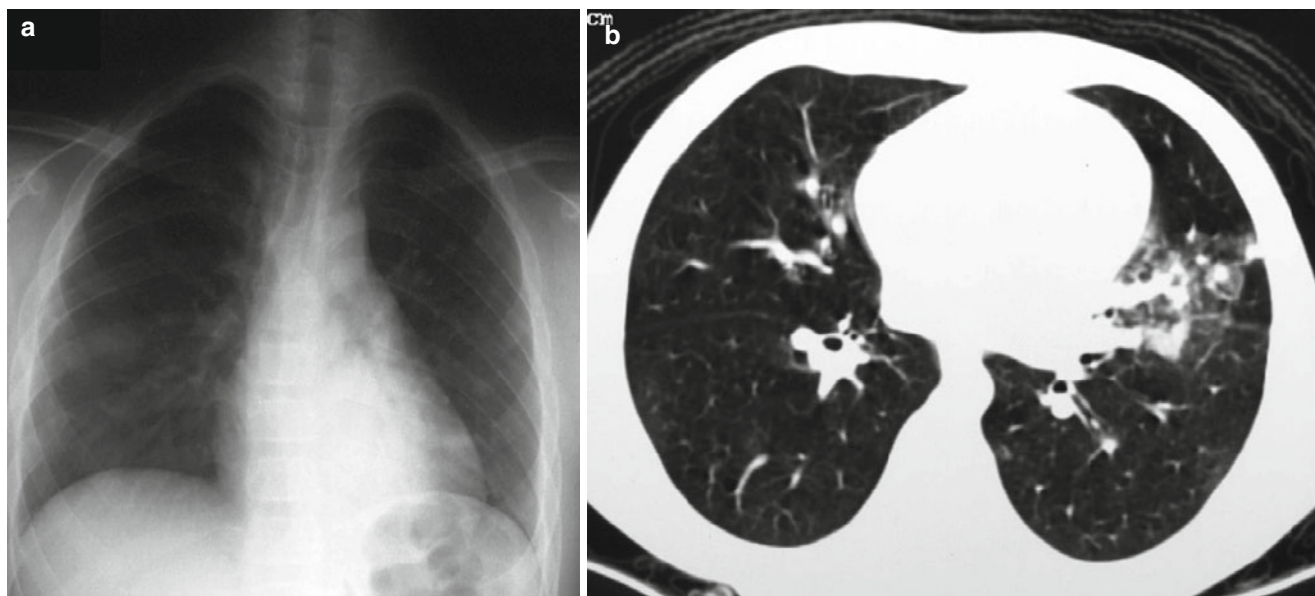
SARS infection. Chest radiograph of a 13-year-old boy 3 days after the onset of fever shows ill-defined haziness in bilateral lower zones (a). An 8-year-old boy with confirmed SARS shows an
